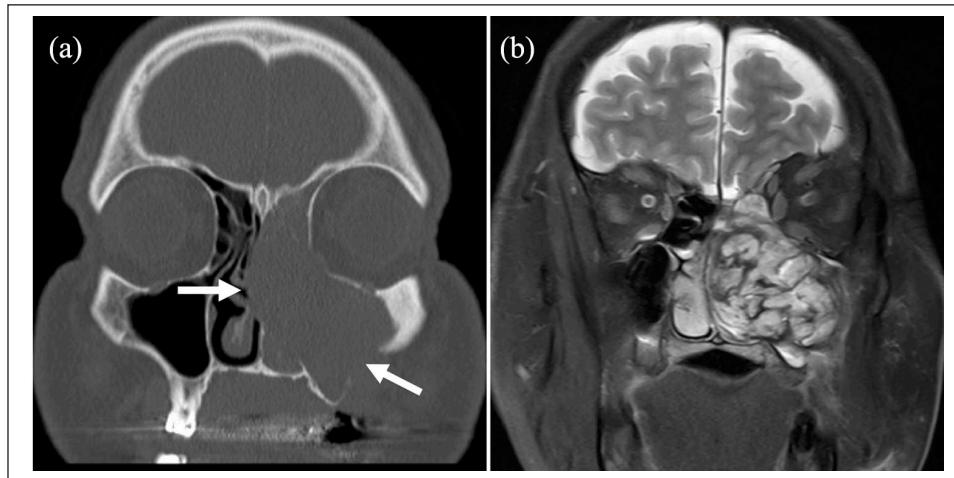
(a) Non-contrast CT of the sinuses revealed a mass with heterogeneous density in the left maxillary sinus, smooth bony destruction of the left medial and lateral maxillary sinus walls, extension into the nasal cavity, and erosion of the left inferior orbital wall. Arrows demonstrate regions of bony destruction with the lesion crossing the midline septum and eroding through the floor of the maxillary sinus and involving the alveolus and (b) magnetic resonance imaging with gadolinium revealed a heterogeneously enhancing mass with foci of high T1 and low T2 signals suggesting blood products.
